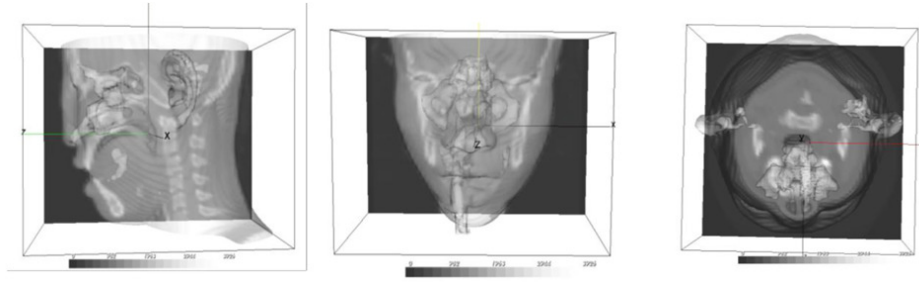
Three different perspectives in 2D from an MRI with matching x,y and z coordinates to form a hypercube. As shown by [6]
